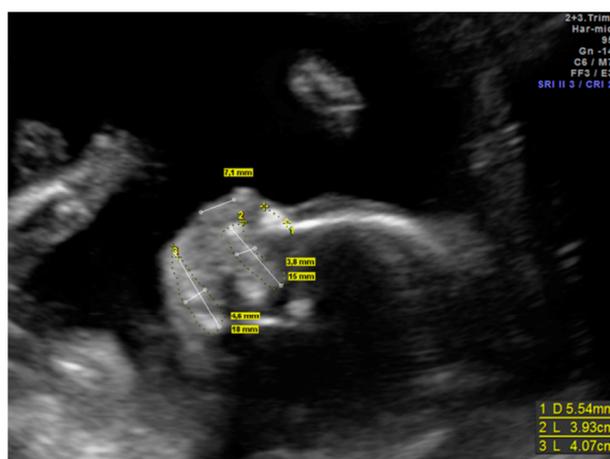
Two-dimensional ultrasound at 20 weeks of gestation. Midsagittal view of the fetal face with an evaluation of the facial profile.
